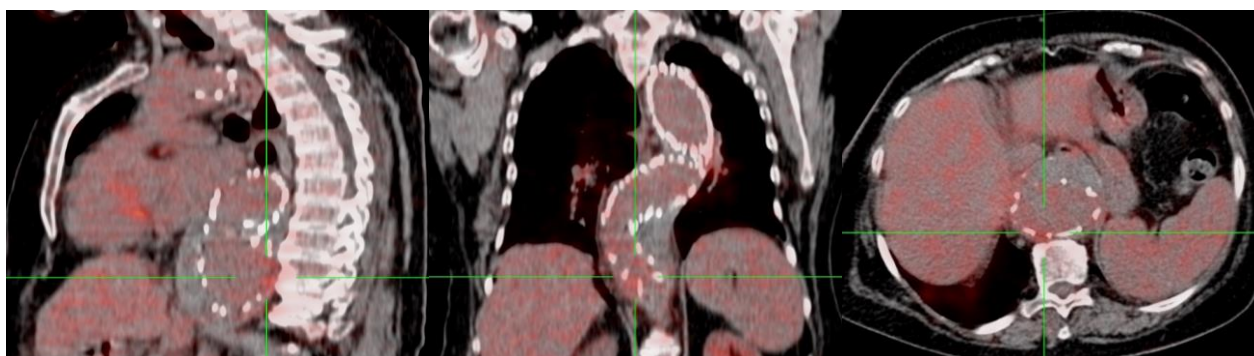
Seventy-one years old female patient with the previous diagnosis of endometrium (Grade 2, Endometrioid carcinoma), oncocytic carcinoma of the right parotid and bilateral breast carcinoma (Lobular carcinoma) is presented. Additionally, history of traumatic aorta dissection operation. After the operation of the secondary malignancy (parotidectomy) the patient was referred for staging/restaging to the FDG PET/CT (Figure 3). The imaging findings demonstrated vasculitis with FDG accumulation at the left subclavian artery as well as previously operated and enlarged aorta from the level of the subclavian artery to the abdomen. Additional to these findings suspicion of the third malignancy in breast tissue was addressed and operations revealed lobular breast carcinoma afterward.
